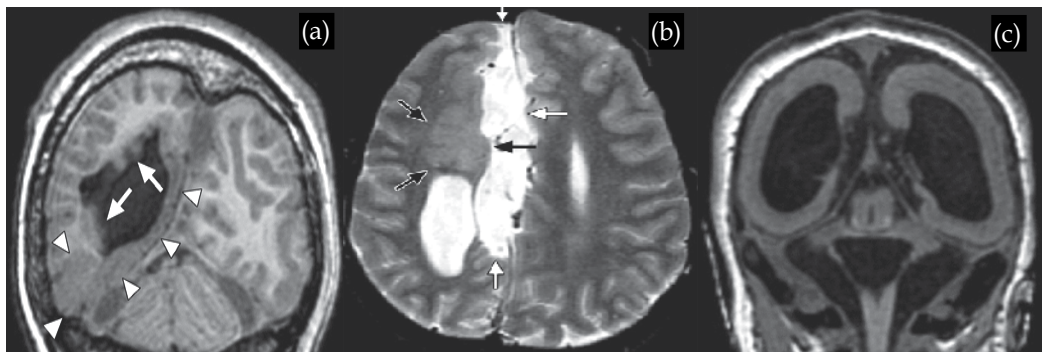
Anomalies of cortical development of varying extent and severity were found in patients with callosal hypogenesis or agenesis. Coronal (a) T1-weighted image in 4-year-old boy shows periventricular nodular heterotopia (arrows) and dysplastic occipital cortex (arrowheads) in addition to dysplastic cerebellum. Axial (b) T2-weighted image in 17-year-old boy shows dysplastic frontal and cingulate cortex (black arrows) adjacent to interhemispheric cyst (white arrows). Coronal (c) T1-weighted image in 6-year-old girl shows lissencephaly with four-layer (Hetts et al., 2006).
